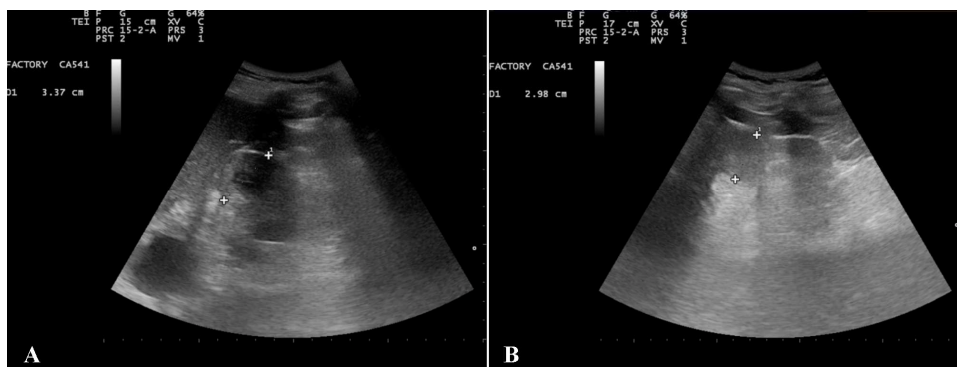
Ultrasonography of kidney metastasis. A 78-year-old man was diagnosed with metastatic renal carcinoma. After 2 weeks of integrative immunotherapy where OA-GcMAF (880 ng/day) was administered by alternating nebulisation and intramuscular injections, one of the kidney lesions taken as representative, measured with ultrasonography, showed a decrease of its diameter from 33.7 mm (panel A) to 29.8 mm (panel B). This corresponds to approximate a 31% overall reduction
